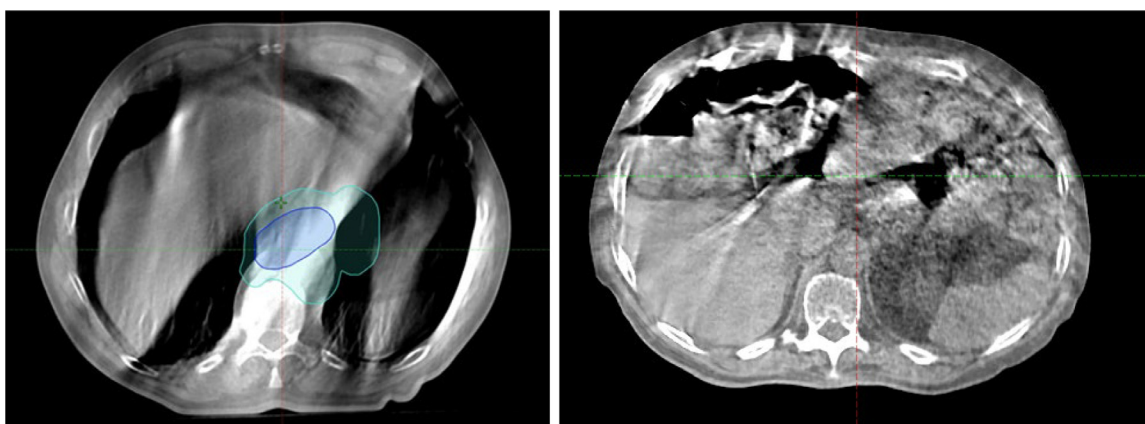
HyperSight CBCT image artifacts. The left figure shows the breathing motion artifacts, and the right figure shows artifacts caused by air inside the patient.
